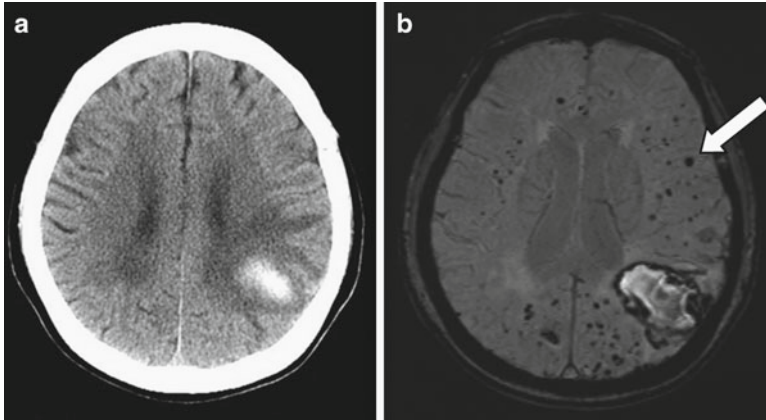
Cerebral amyloid angiopathy (CAA). In this 70-year-old woman with left parietal lobar ICH (a, CT scan), MRI susceptibility-weighted imaging reveals dozens of small hypointensities indicating lobar microbleeds (b, arrow) not apparent on CT scan, consistent with probable CAA
